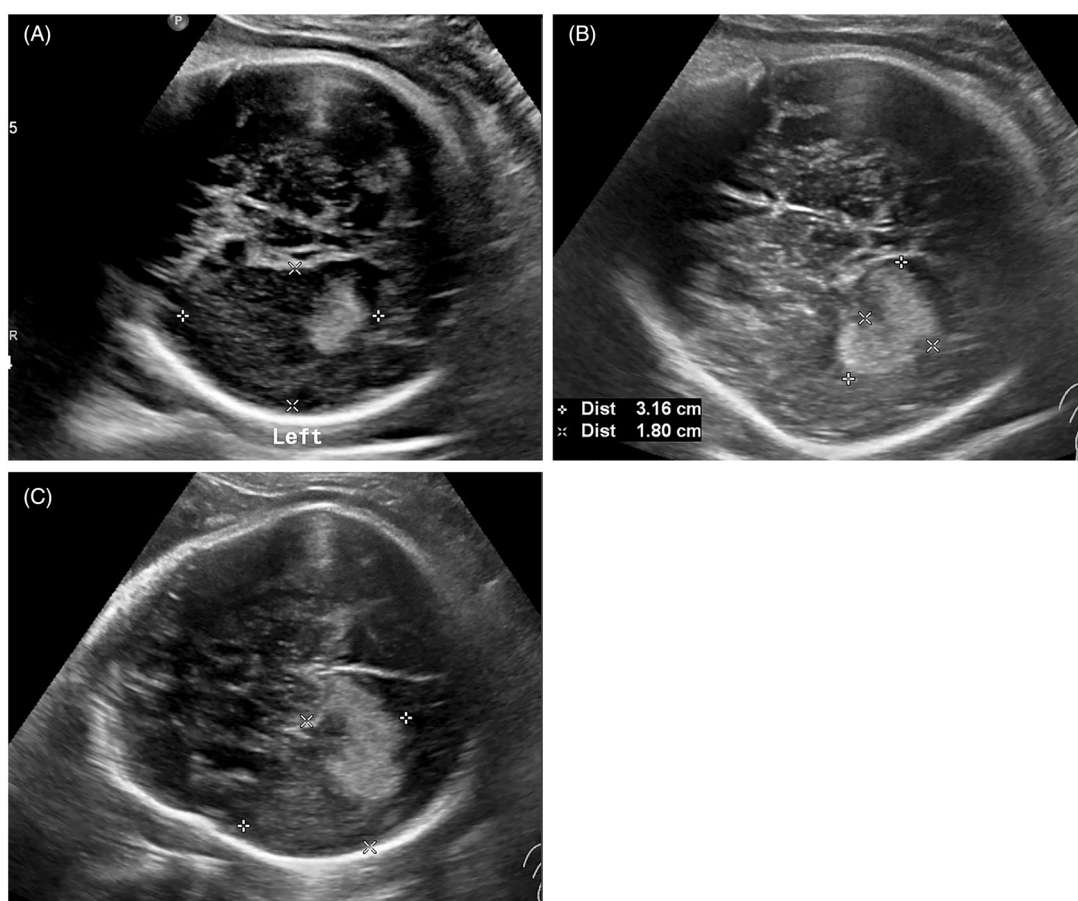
Ultrasonography (US) findings at 38 + 2 (A), 39 (B), and 39 + 2 (C) weeks, showing a slight midline shift. (A) the axial US image of fetal brain reveals an echogenic area in the tumor. (B, C) sonograms showing large bleeding area.
